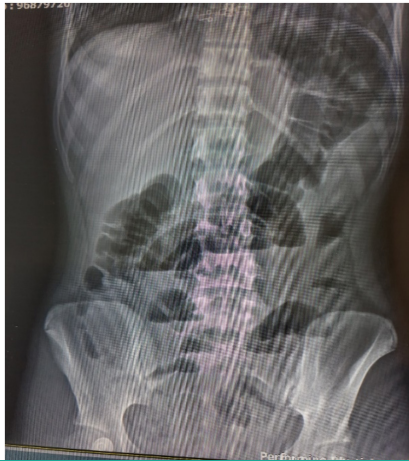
In the standind direct abdominal X-ray, air-fluid levels, which is the radiological finding of ileus
